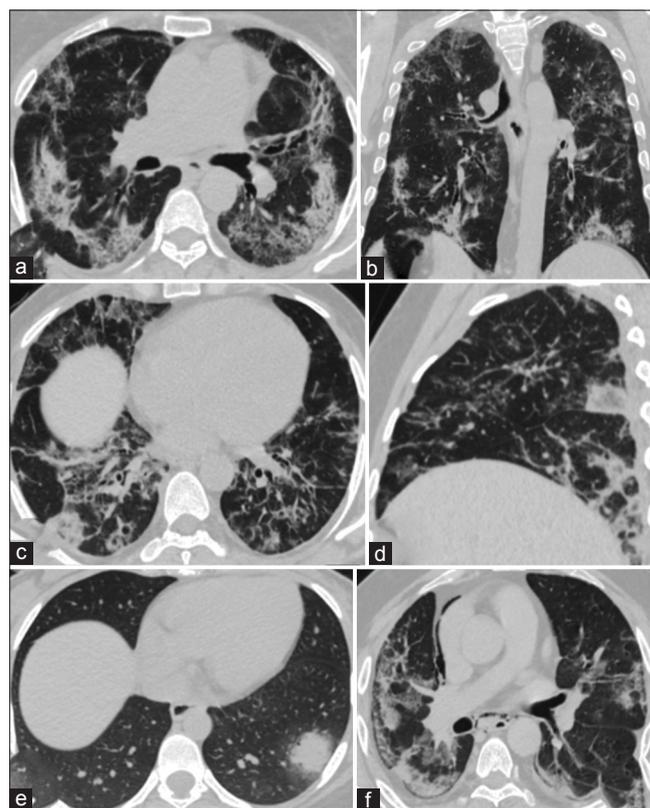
Axial computed tomography (CT) images showing ground glass opacities (GGOs), linear opacities, fibrous stripes, and bronchial distortion with bronchial wall thickening (a and b). Axial and sagittal images of a patient showing the patchy area of GGOs with surrounding consolidation giving a "Reverse Halo" sign (c and d). Another axial CT image showing pulmonary nodule with surrounding GGOs giving a "Halo" sign in image (e). Image (f) shows GGOs with linear opacities and spontaneous pneumomediastinum
